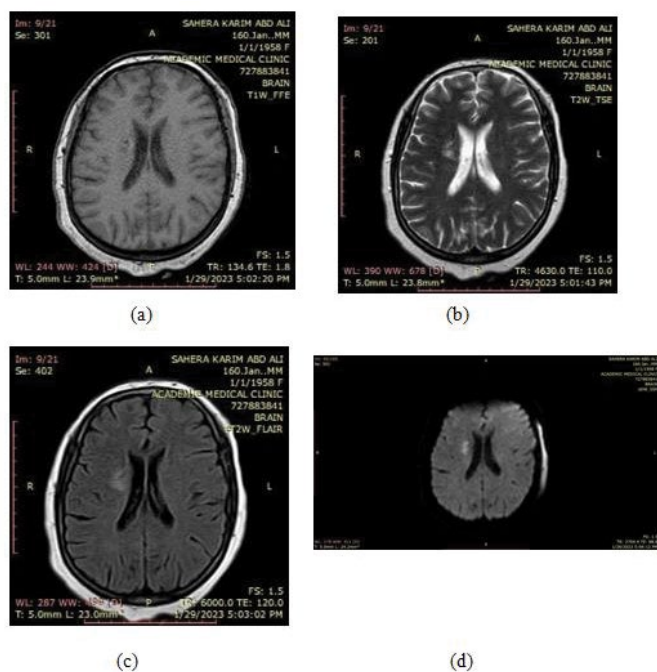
States the acute stroke taken by (a) (T1W) sequence, (b) (T2W) sequence, (c) (FLARE) sequence, (c) (DWI) sequence.
